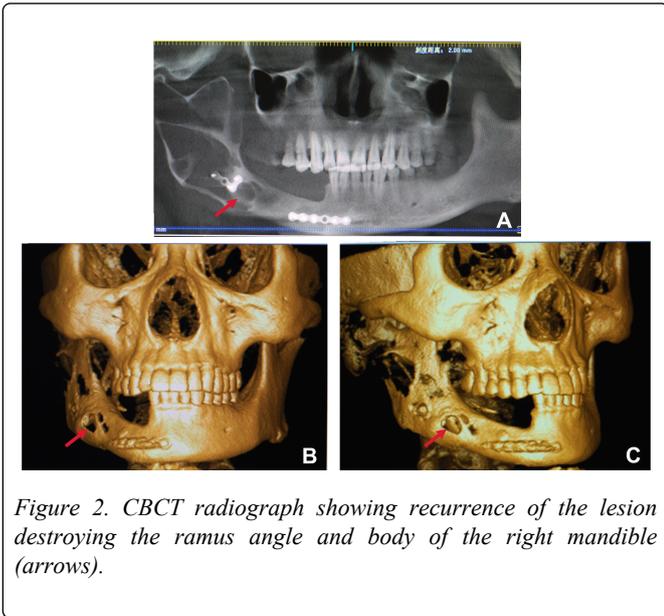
CBCT radiograph showing recurrence of the lesion destroying the ramus angle and body of the right mandible (arrows).
